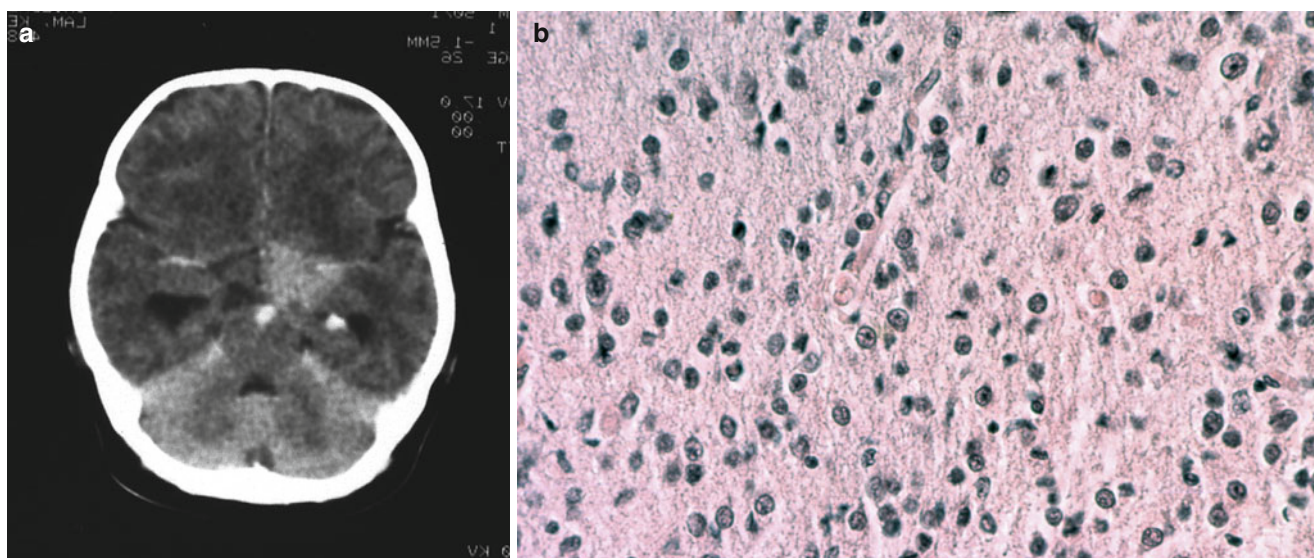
Anaplastic astrocytoma. Two-month-old male with hydrocephalus and a mass in the left and right thalamus. (a) CT scan shows the infiltrative thalamic mass. (b) The tumor is hypercellular with moderate nuclear and cytoplasmic pleomorphism. The nuclei are darkly
